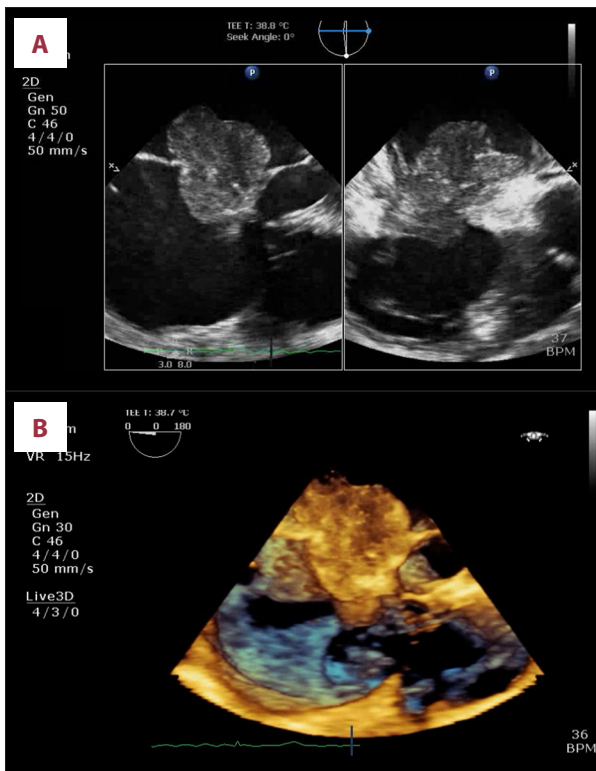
Other cardiac imaging demonstrated the cardiac mass. (A) Transesophageal echocardiogram re-demonstrated the mass. (B) Three-dimensional acquisition of the cardiac mass obtained during transesophageal echocardiogram. (C) Cardiac magnetic resonance imaging confirmed a 3.8×4.3×5.6 cm mass between the atria.
